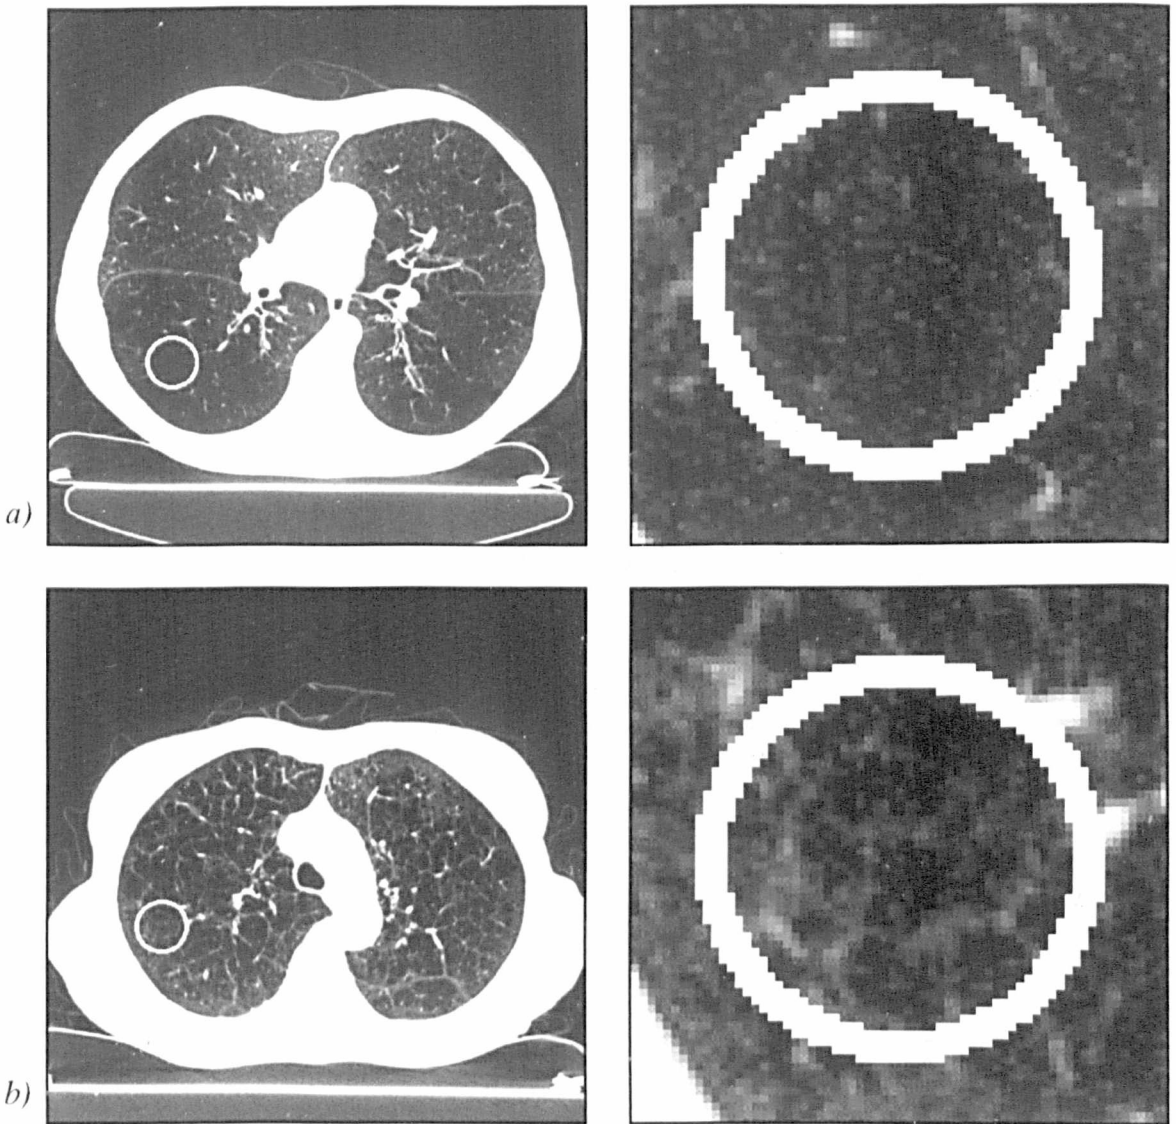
Five examples of high-resolution CT scans of the chest (window settings: level = -500 H.U., width = 1000 H.U.). On each image, the circle highlights a region of interest (ROI) that is characteristic of a particular condition. An enlarged view of the ROI is also shown on the right of each image. *a)* Panlobular emphysema: destruction of the lung parenchyma results in homogeneous hypo-attenuated areas. *b)* Severe centrilobular emphysema: the CT appearance of the disease superficially resembles air cysts.
